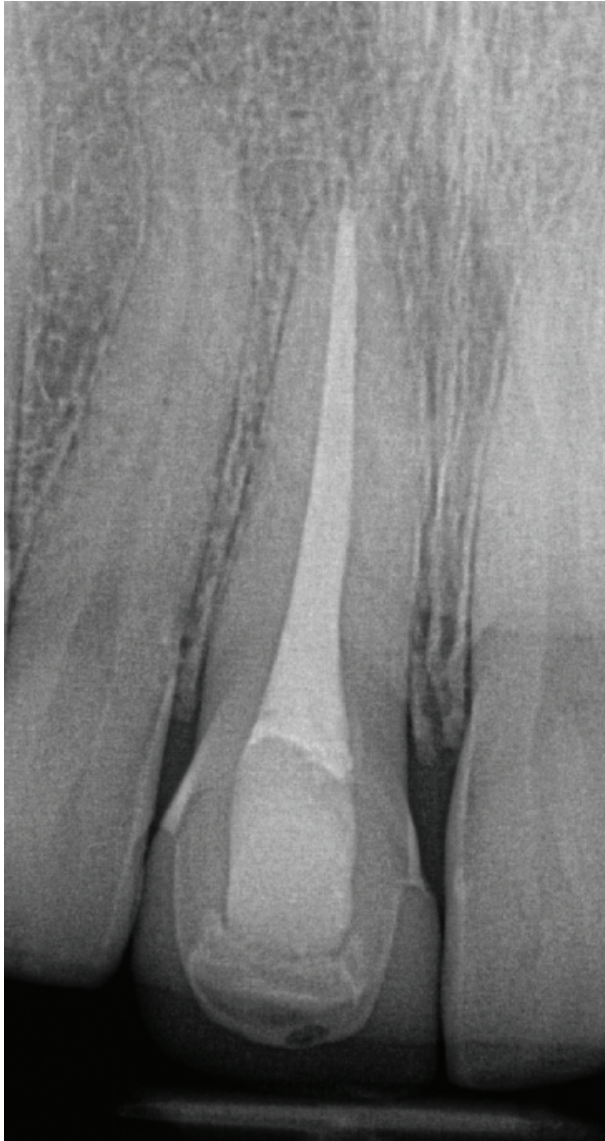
Final radiograph
